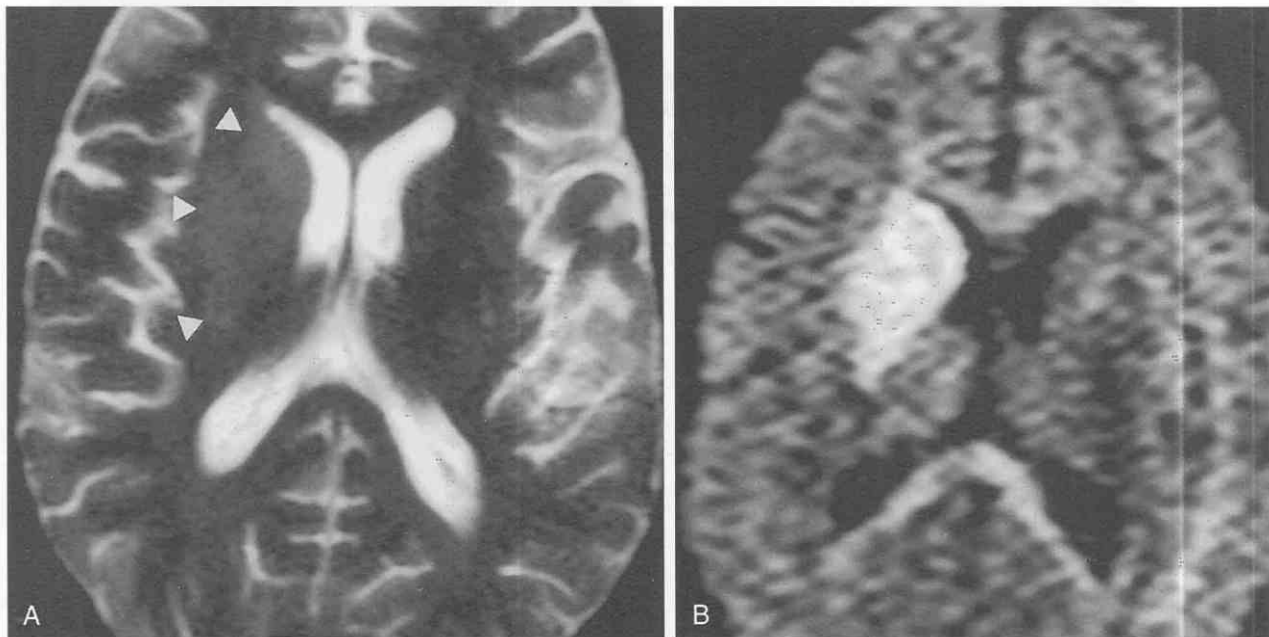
Acute dissection of the internal carotid artery. A, T2-weighted axial image shows minimal increased signal within the right basal ganglia (triangles). B, Diffusion-weighted ($b = 970$), echo-planar image shows hyperintensity within the same region that is substantially more conspicuous. Diffusion-weighted images have greater sensitivity for acute infarction.
